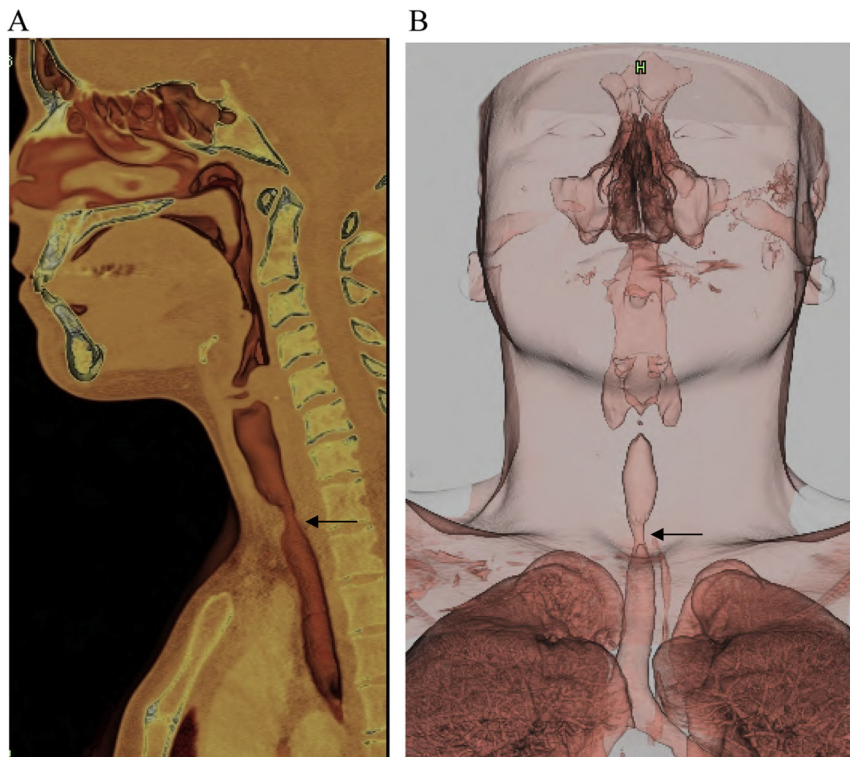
(A, B). 3D reconstruction of the CT scan shows localized area of severe tracheal narrowing (arrow). The lesion is localized in the extrathoracic trachea, adjacent to the level of the thyroid gland, about 3.5 cm below the vocal cords.
